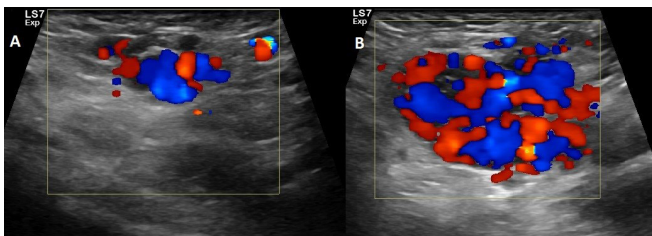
(A) Color Doppler imaging shows multiple dilated veins with blood flow and (B) the mass shows dilatation and increased flow during the Valsalva maneuver (Case 1).
